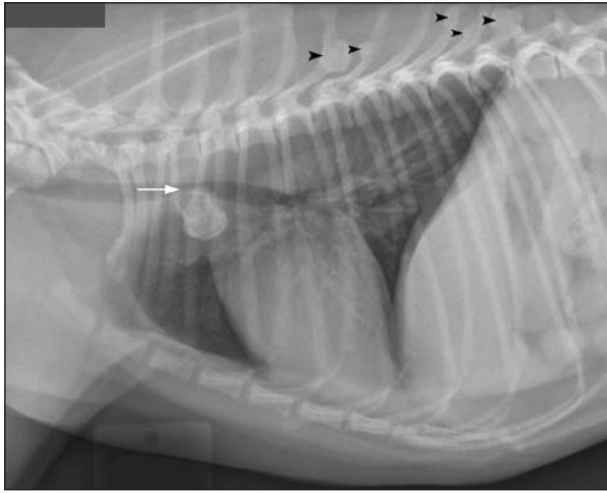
Same radiographic view as Figure 1. Notice the ventral compression of the trachea (white arrow) and exostoses on several spinous processes (black arrowheads).
